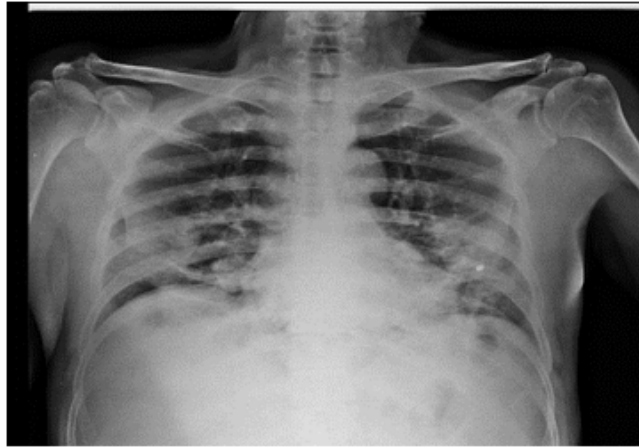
Chest X-ray upon patient admission.
